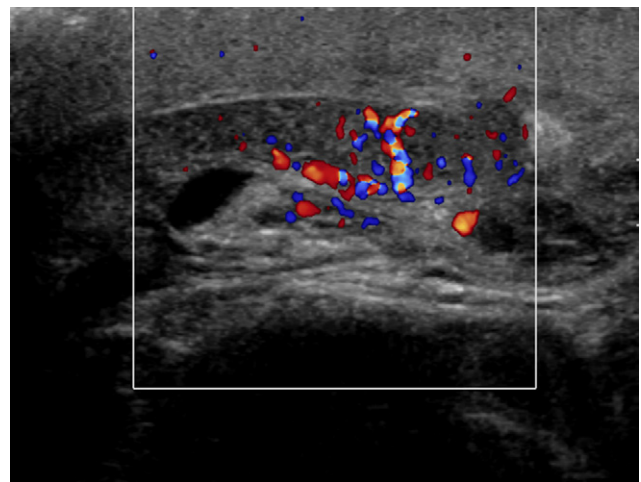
Colour Doppler sonogram along the axis of the right epididymis.
